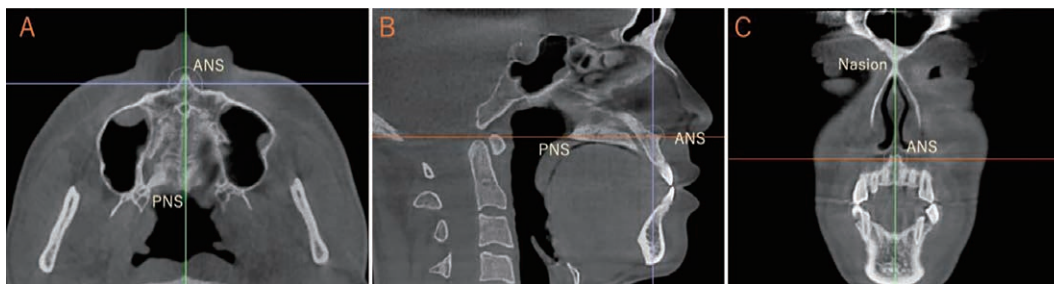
Cone-beam CT sections used to obtain the measurements. A. axial section ; B. sagittal section ; C. coronal section.
